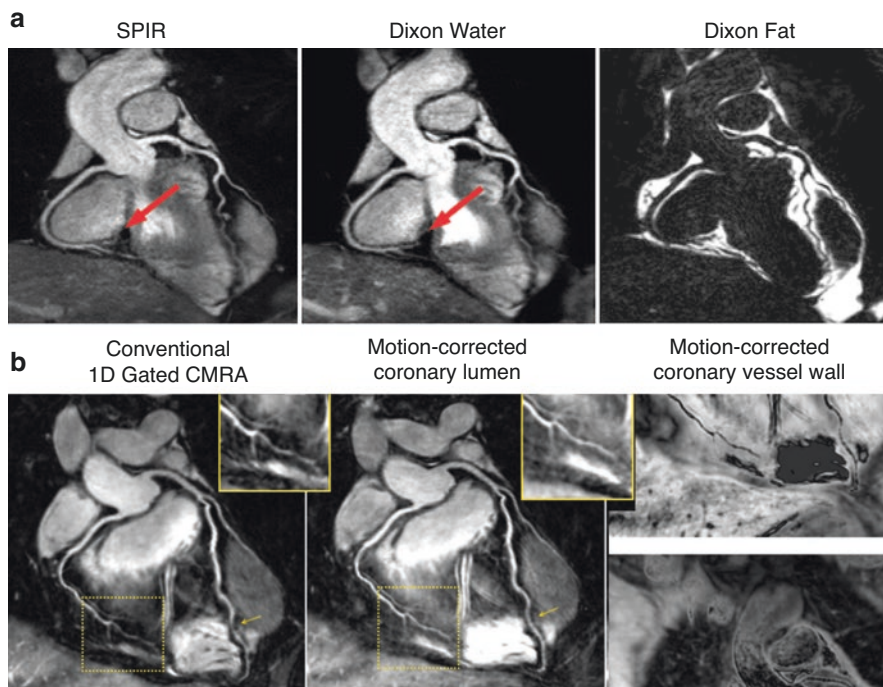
Innovations in coronary MR imaging. (a) Water/fat coronary MR angiography improves fat suppression and contrast-to-noise ratio at 3 T compared to conventional fat suppression (SPIR) (adapted from Nezafat, M., Henningsson, M., Ripley, D.P. et al. *Coronary MR angiography at 3T: fat suppression versus water-fat separation*. Magn Reson Mater Phy (2016) 29: 733). (b) Interleaved T_2 -preparation can be used for simultaneous imaging of the coronary vessel wall and coronary lumen. (Adapted from Cruz G, Atkinson D, Henningsson M, et al. *Highly efficient non-rigid motion-corrected 3D whole-heart coronary vessel wall imaging*. Magn Reson Med. 2017;77:1894–908)
